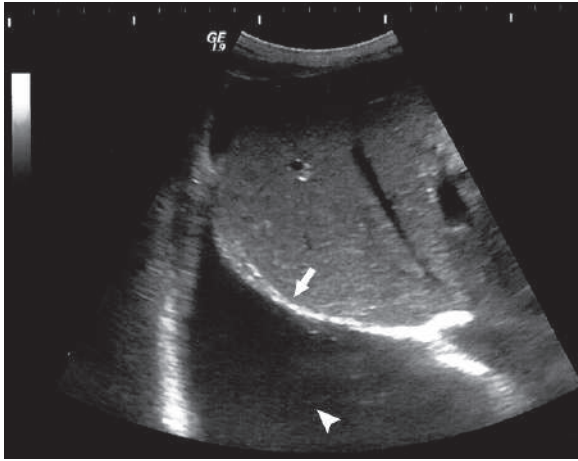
Transverse ultrasound image shows right-sided pleural effusion (*arrowhead*). The diaphragm can be visualized as a hyperechoic line separating the right lung base from the liver (*arrow*)
